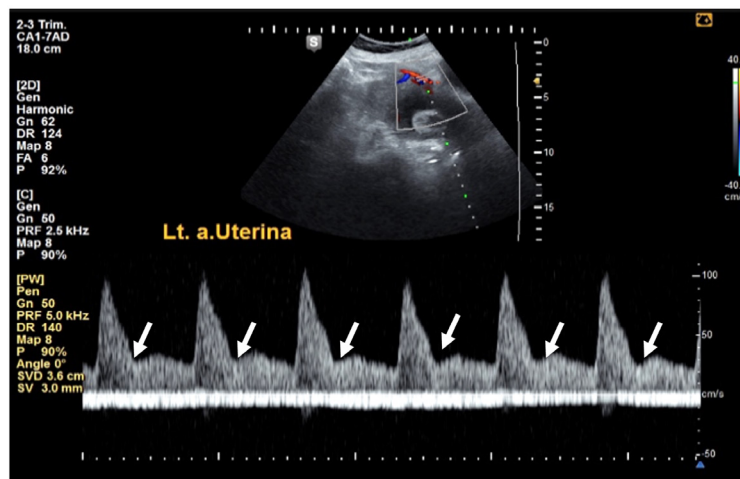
Left uterine artery. Ultrasound examination results for the 6<sup>th</sup> pregnancy, left uterine artery persistent notching at 18<sup>th</sup> weeks of pregnancy (white arrow).
